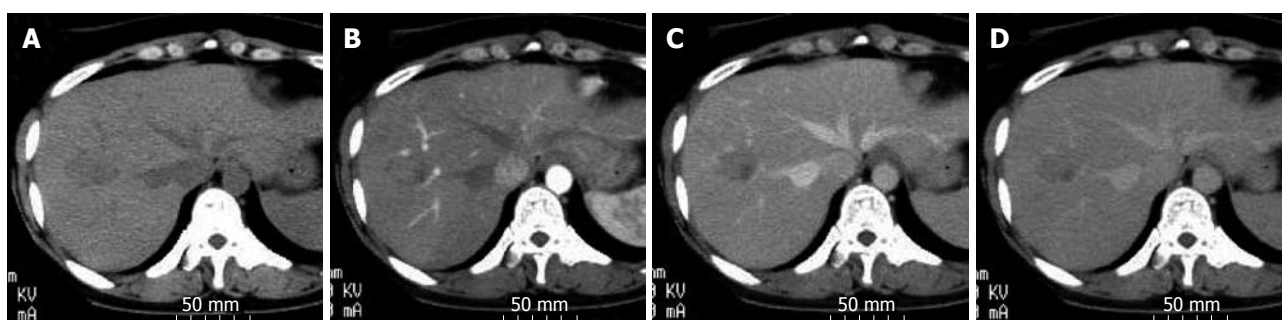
CT in July 2007. A: Plain; B: Arterial phase; C: Portal phase; D: Delayed phase.
